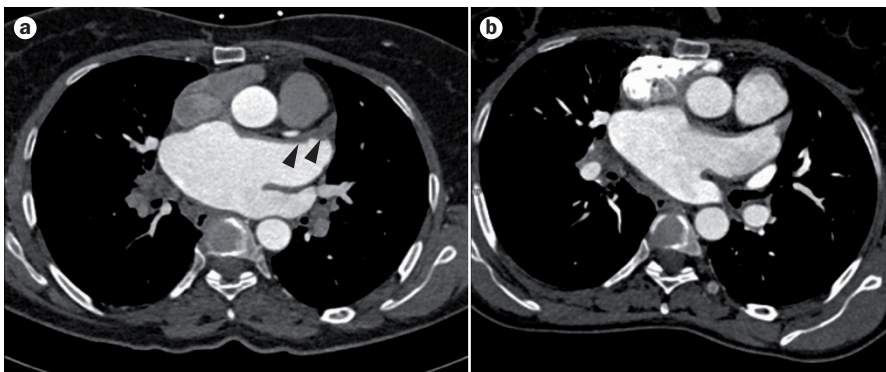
Differential diagnosis of thrombosis and SEC using multidetector computed tomography. a | When a patient is in the supine position, SEC (arrowheads) can mimic thrombosis. b | However, when the patient is in the prone position, the SEC disappears. Abbreviation: SEC, spontaneous echocardiographic contrast.
